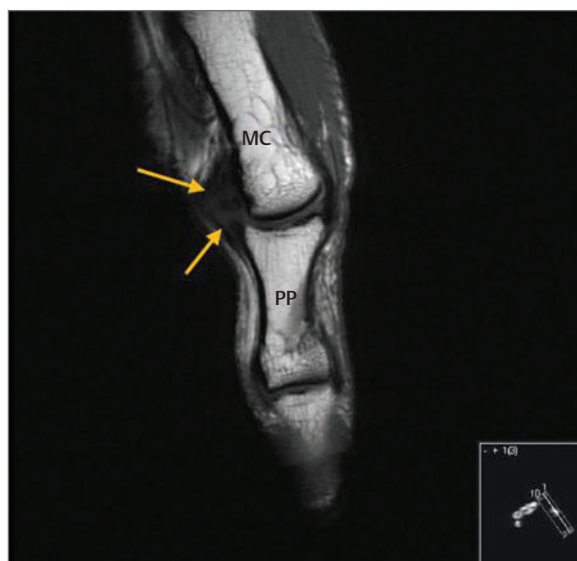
Thumb-MRI coronal T1 images of the ulnar collateral ligament demonstrated in ► Fig. 6.54. There appears to be a subluxation of the proximal phalanx at the metacarpophalangeal joint. In addition, there is a rupture of the ulnar collateral ligament in its midsubstance. It may be seen that the information obtained with the ultrasound in ► Fig. 6.55 is just as accurate as the MRI scan. In addition, the ultrasound scan may be undertaken in an office setting and include dynamic imaging. MC, metacarpal; PP, proximal phalanx; yellow arrows, ulnar collateral ligament.
